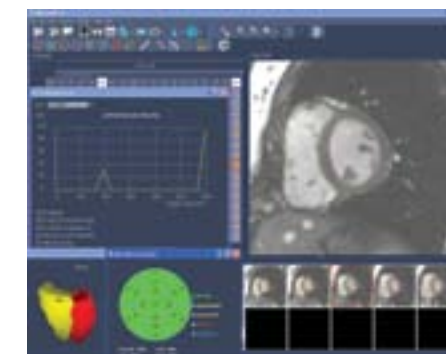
Sample MRI heart study with quantitation of ventricular ejection fractions and myocardial mass.
